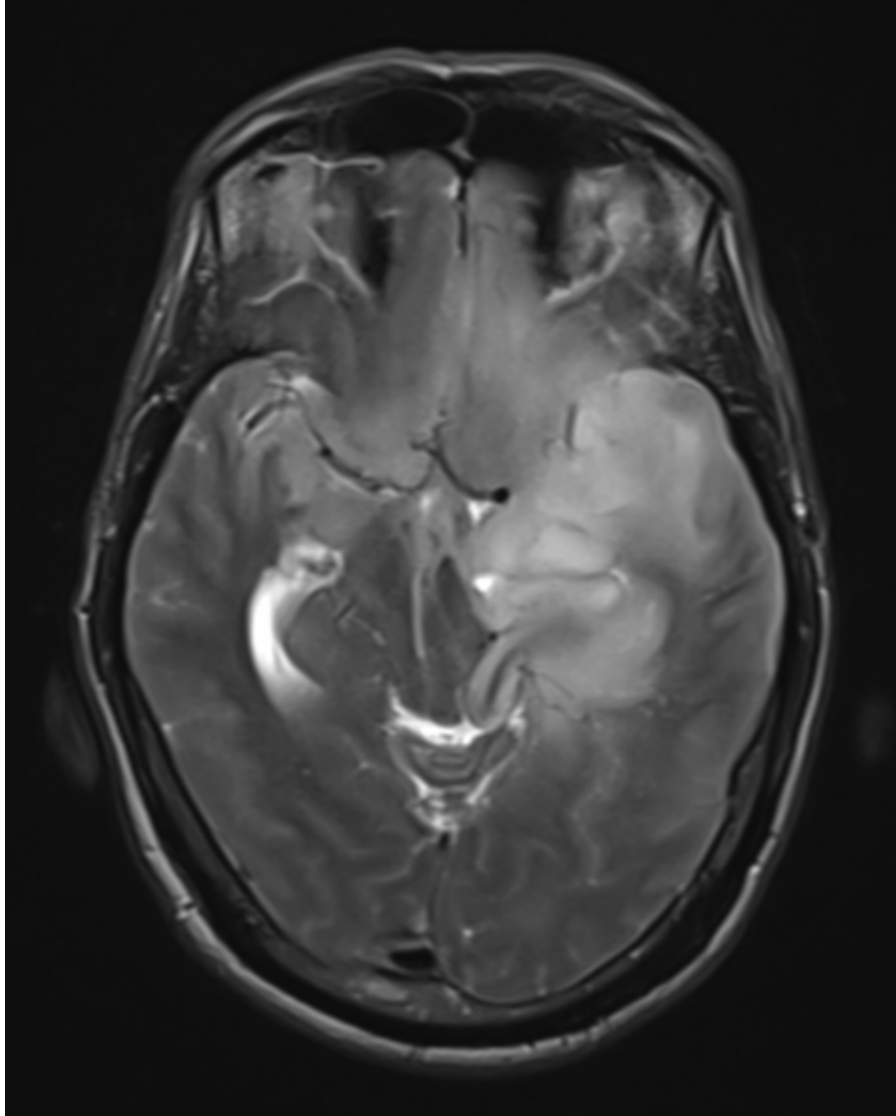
MRI brain – 3704/18, Temporal glioblastoma (IDH1 positive) – ring enhancement absent
